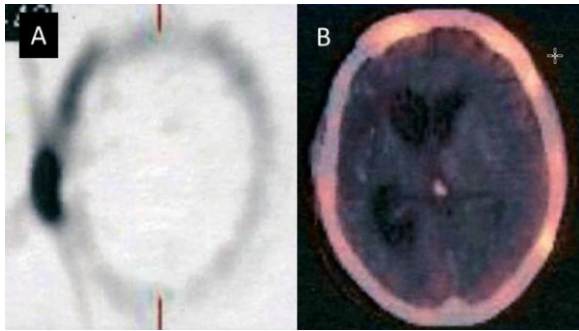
A) A SPECT scan with Tc-99m-labeled anti-granulocyte monoclonal antibodies shows pathological tracer accumulation at the cranioplasty site, indicating active infection B) A 2-year follow-up using the same methodology rules out any residual infectious foci.
